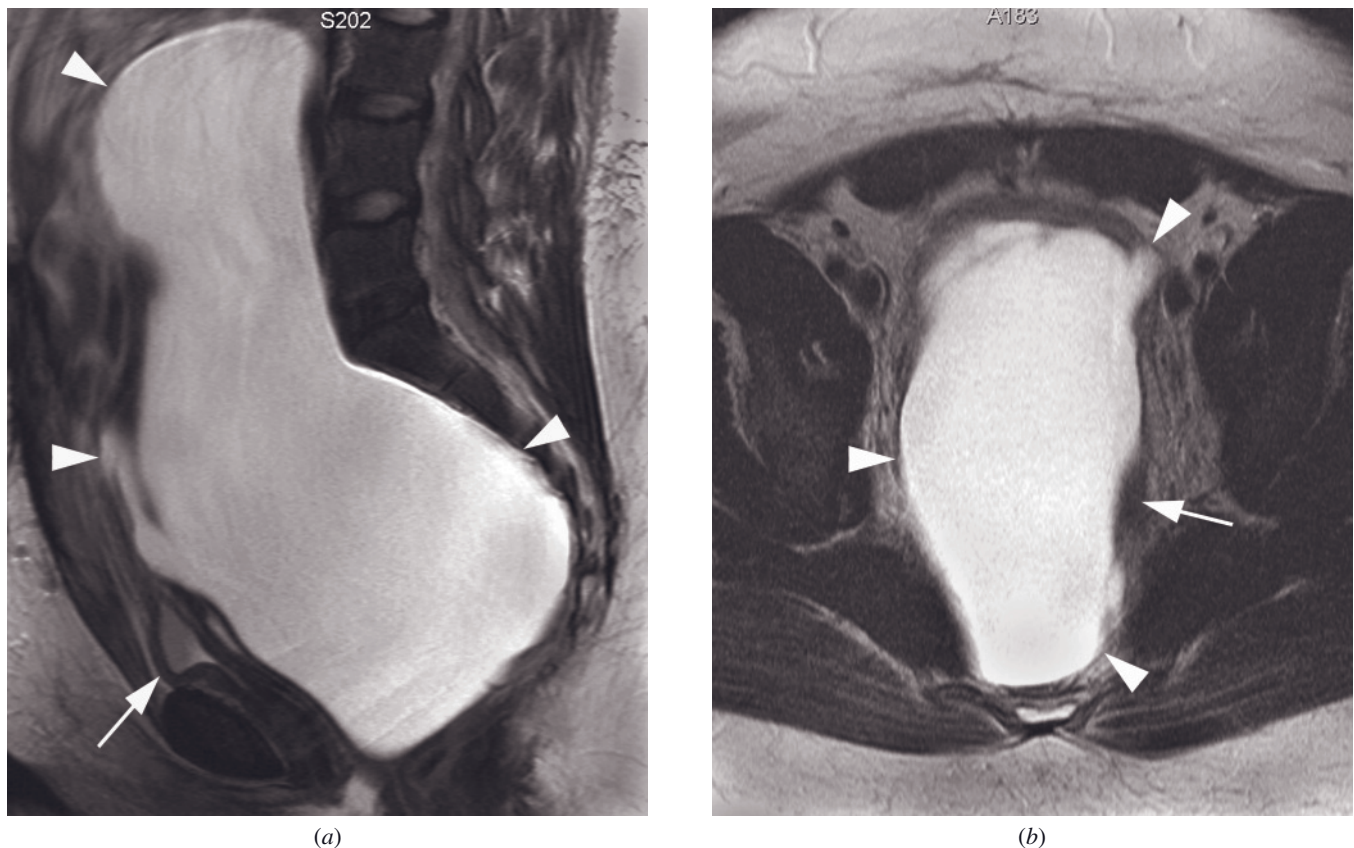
Peritoneal inclusion cyst. Sagittal (*a*) and transverse (*b*) T2-weighted ETSE images in a woman with a history of abdominopelvic surgery. A large, irregularly shaped cystic mass (arrowheads, *a, b*) displaces the bladder (arrow, *a*) and sigmoid colon (arrow, *b*). The mass was found to be a benign peritoneal cyst.
